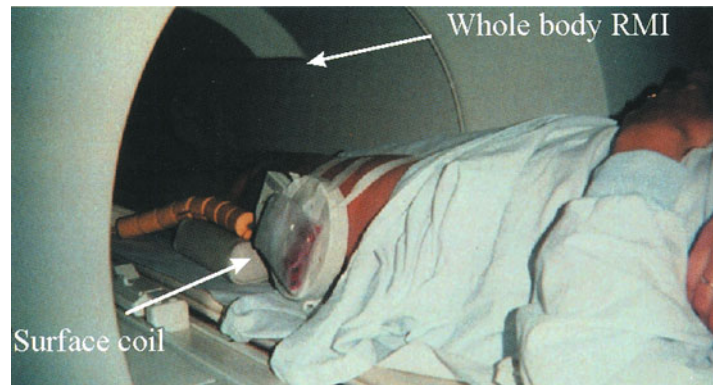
MRI total body device with additional surface coil for skin and subcutis imaging (Courtesy of Prof. Joffre, Radiology Department, Ranguel University Hospital, Toulouse, France)
